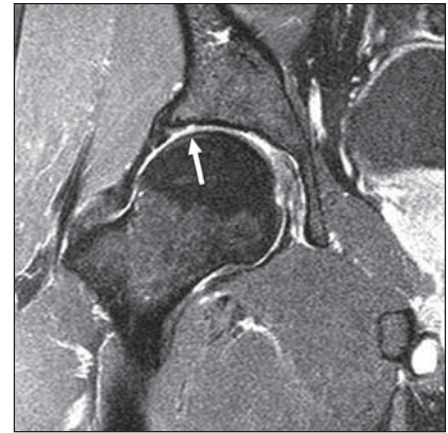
Sagittal fat-suppressed T1-weighted image with IV gadolinium enhancement performed after exercise and delay in a 54-year-old woman. Contrast outlines what was interpreted as partial separation of anterior superior labrum, with some fraying (*arrow*). Arthroscopy did not reveal a labral tear; hence, this was a false-positive result.
